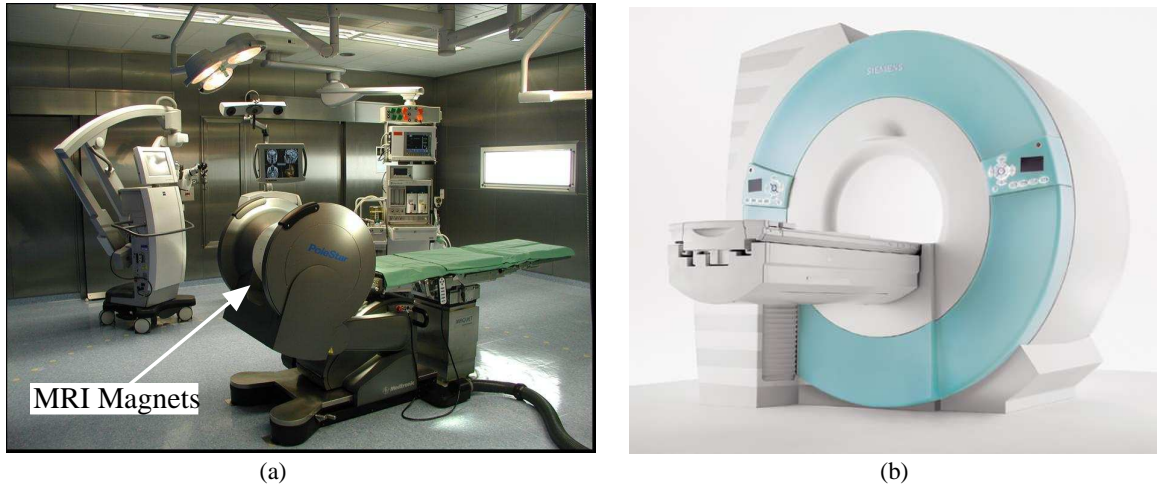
Interventional MRI machines, (a) PoleStar system (courtesy D. Simon, Medtronic Inc.) and (b) the Magnetom Espree "open bore" system from Siemens AG (courtesy C. Lorenz, Siemens Corporate Research Inc.).
